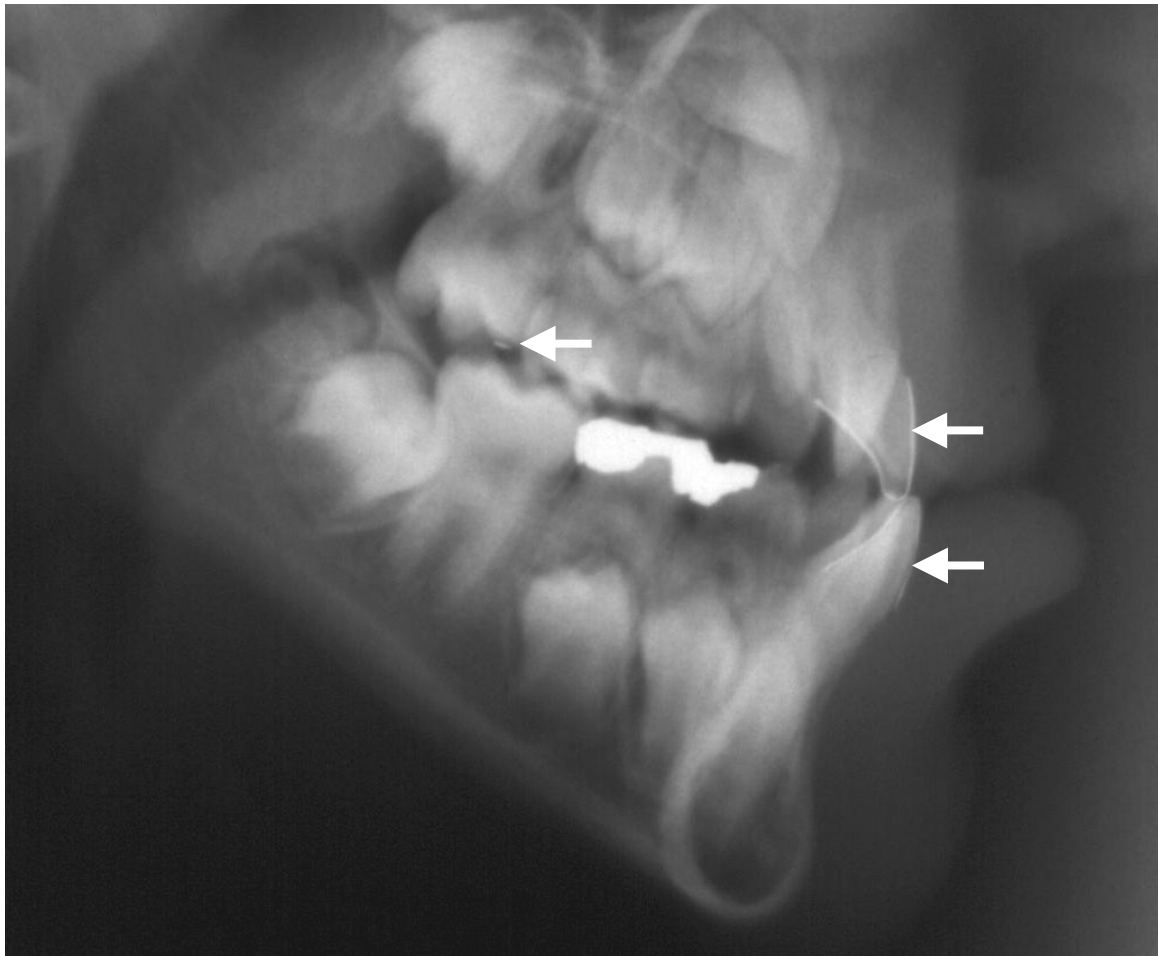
The relevant area of the lateral cephalometric radiograph in figure 8.4B enlarged to provide clear visualisation of the markers.
